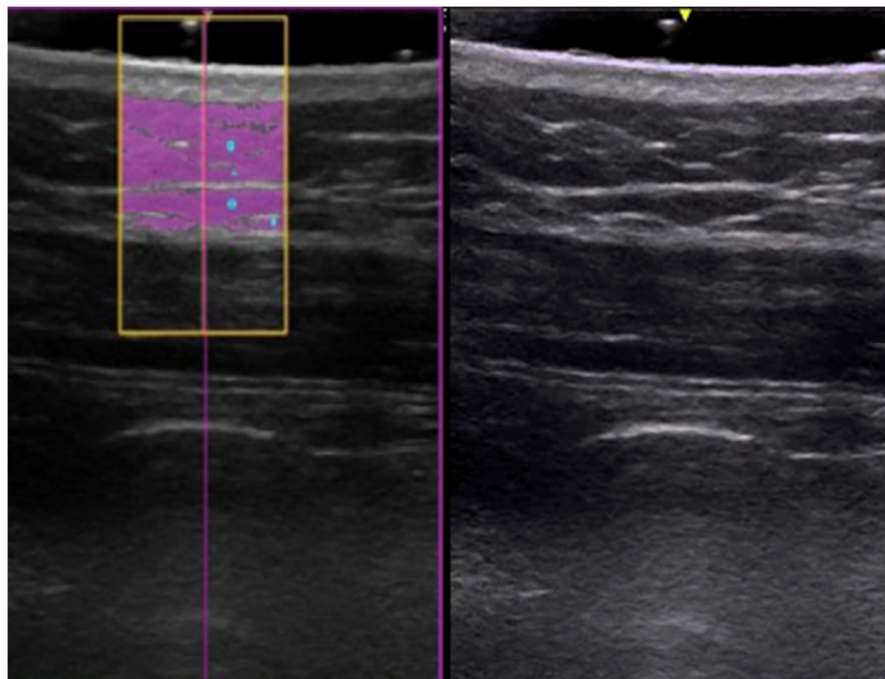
Ultrasound image of SAT (13)
